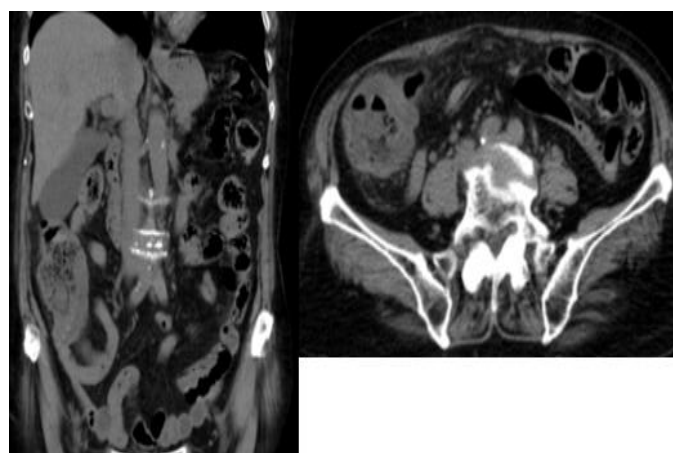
CT scan showing inflammatory process at right lower quadrant
